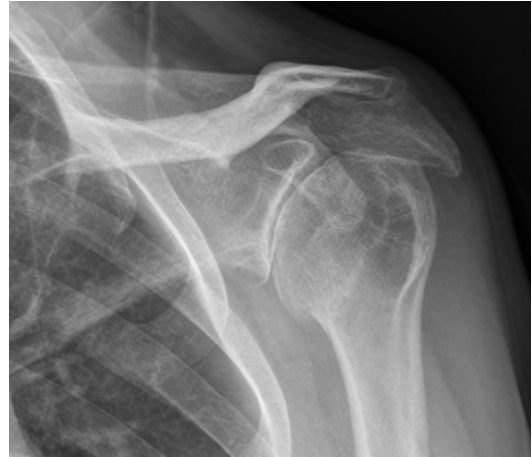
Shoulder AP radiograph of a patient with pain and bleed episodes who has developed moderate degenerative changes with cysts in the humeral head and glenoid
